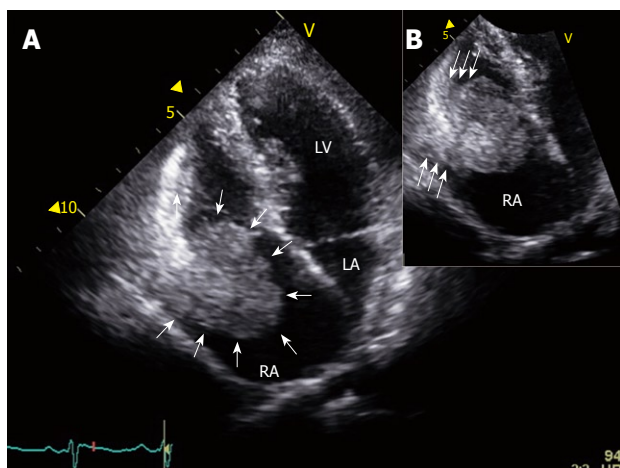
Transthoracic echocardiography. A: A mobile, round, spherical, and echogenic mass (white arrows) is seen adjacent to the lateral right atrial wall on an apical four chamber view of the transthoracic echocardiography; B: A magnified image of the right atrial mass shows a pedunculated character with a broad stalk (tris-arrows). RA: Right atrium; LA: Left atrium; LV: Left ventricle.
